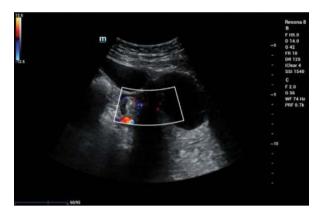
The mass is located adjacent to the cyst, and color Doppler ultrasound shows a spiral pattern of blood flow within the mass
